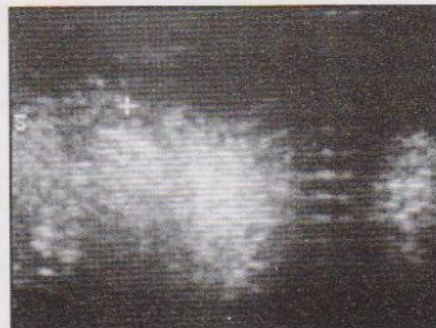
Ultrasound without Appliance.
